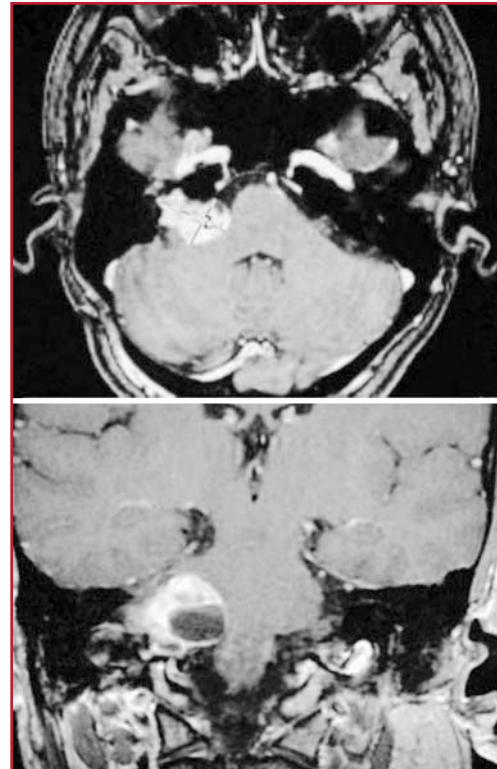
MRI scans showing the evolution of an FNS after radiosurgery, with development of a cyst.
